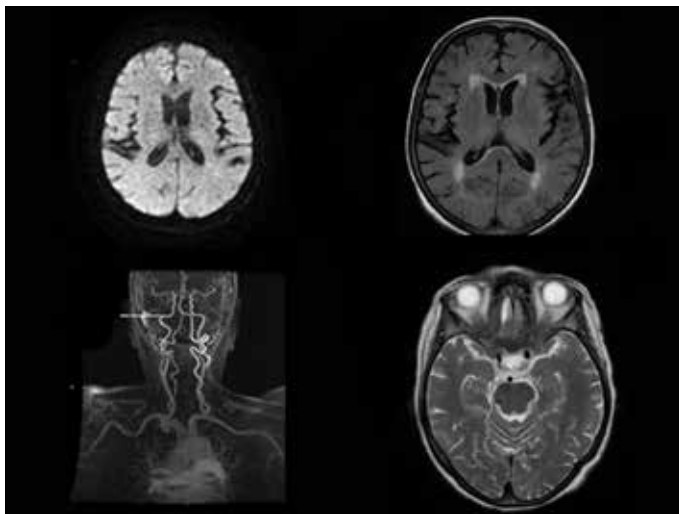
Cranial MRI (T2 axial, T2 flair, diffuse axial) and MR angiography
